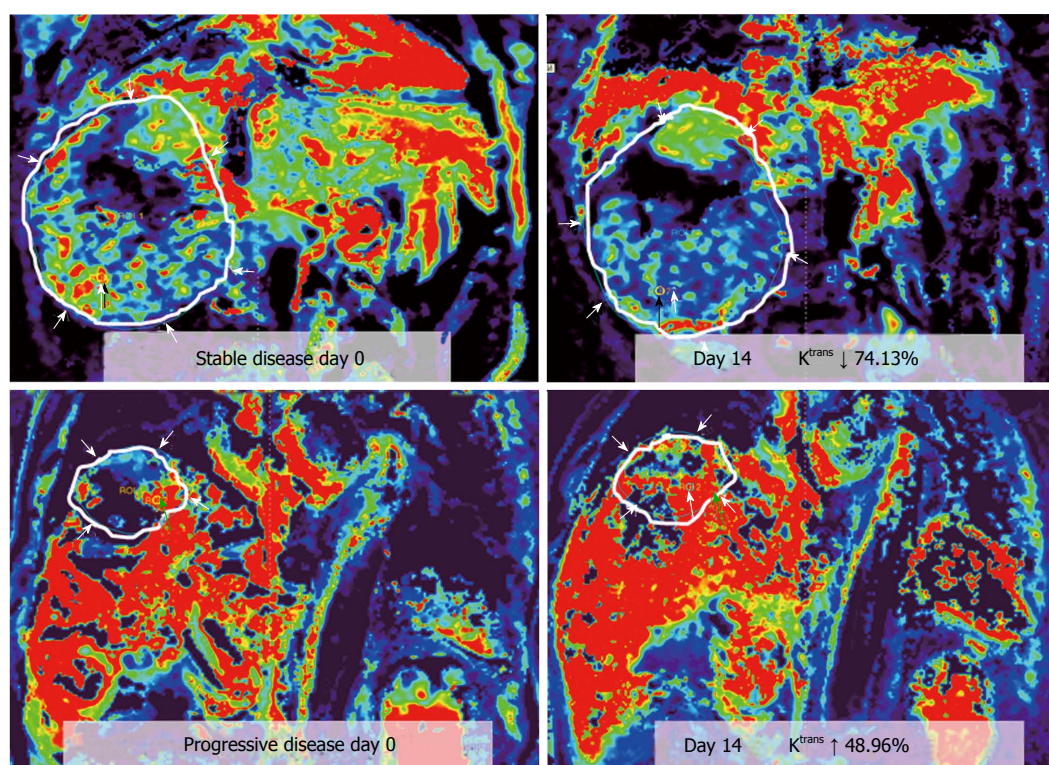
Representative dynamic contrast-enhanced magnetic resonance imaging K^{trans} color maps before treatment (day 0, left hand side) and day 14th after treatment (right hand side) in two advanced hepatocellular carcinoma patients. Corresponding hypervascular area was indicated by red color. region of interests analysis is more sensitive based on hypervascular part than entire tumor, with mean values. K^{trans} is a good diagnostic biomarker in differentiation between stable disease (SD, upper row) and progressive disease (PD, lower row) in two patients with hepatocellular carcinoma. Difference of K^{trans} (ΔK^{trans}) between SD and PD measured on hypervascular part and entire tumor are both significant. (From reference [58], reprint with permission).
